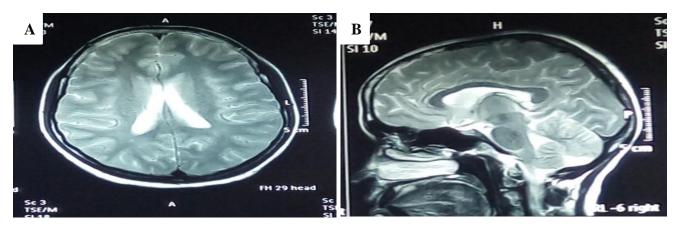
MRI. A) MRI of the brain axial. B) MRI of sagittal view show normal study.
